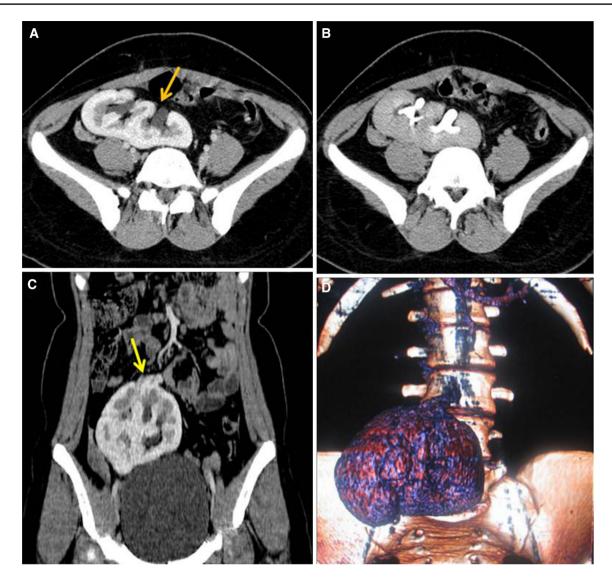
Pancake kidney. Axial CT images (a, b) showing both the kidneys are low lying and fused. Coronal reformatted CT image (c) and VRT (d) image show both the kidneys are fused enface and low lying
